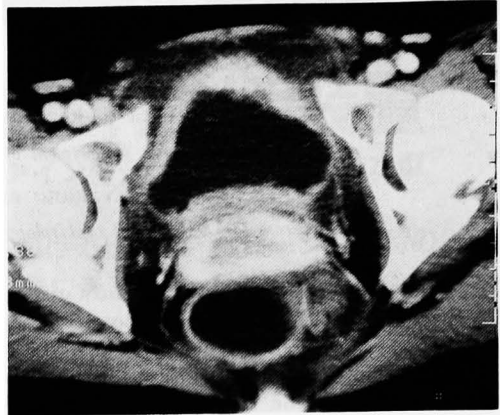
Thickening of urinary bladder and contract effects in the serosa and mucosa were shown on CT
